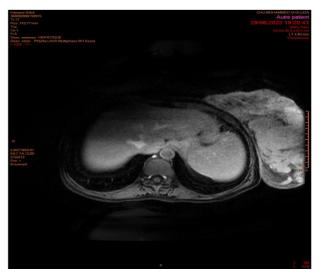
MRI after contrast injection
